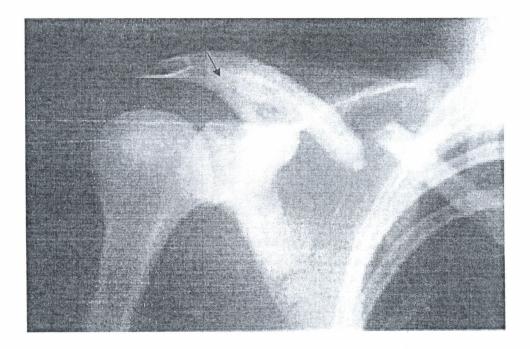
AP radiograph showing midshaft fracture of clavicle.
